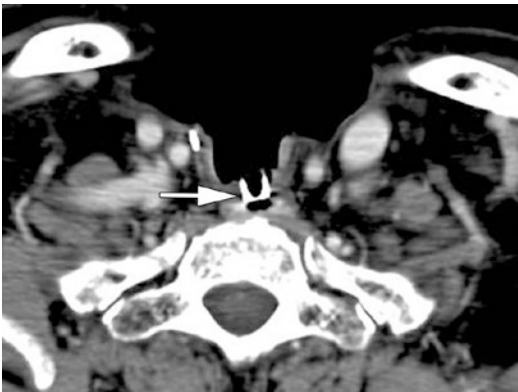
Axial CT image at the level of the tracheostomy, in a patient who underwent total laryngectomy. Normal appearance of a voice prosthesis (arrow), placed through the tracheo-esophageal septum
